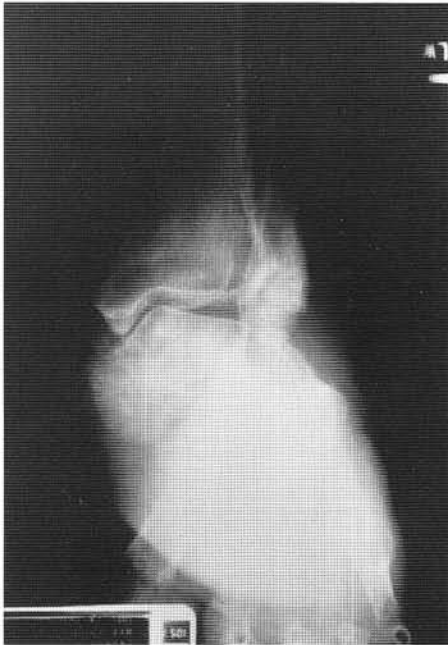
Preoperative A-P radiograph. Note the medial dislocation of the talus.
